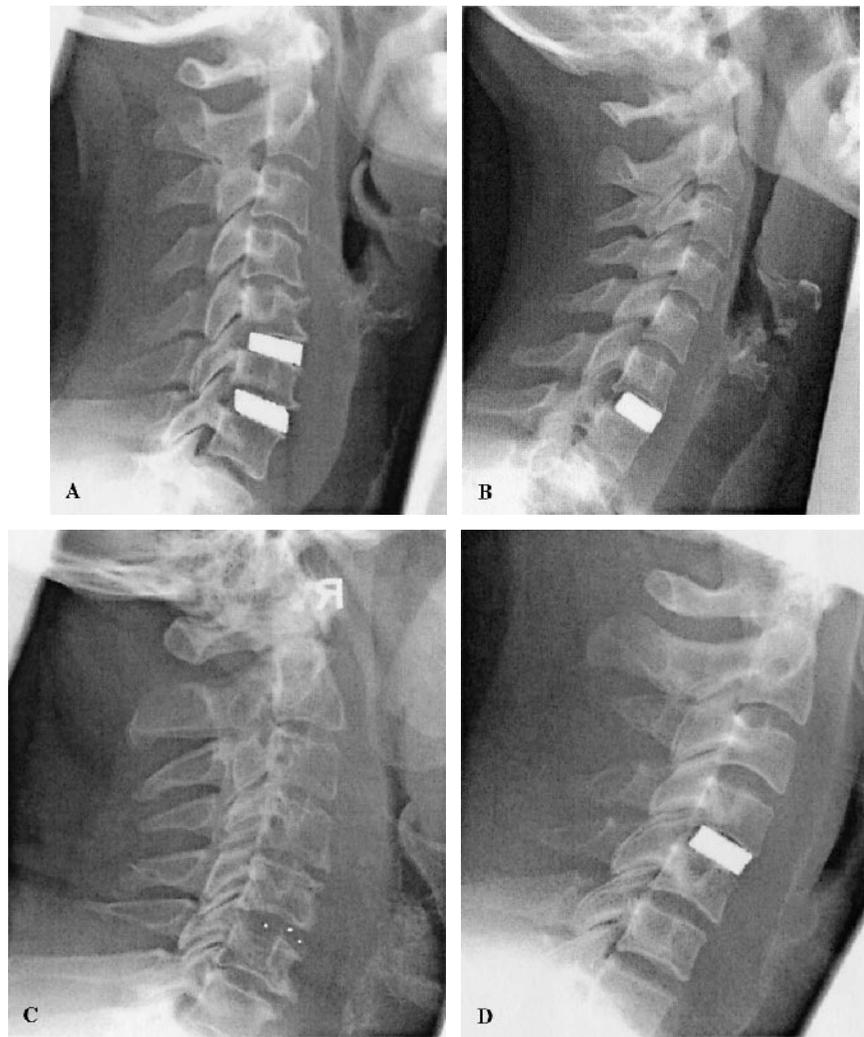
Radiographic contrast of (A) Weber, (B) Intromed, (C) AcroMed, and (D) Cespace spacers.
